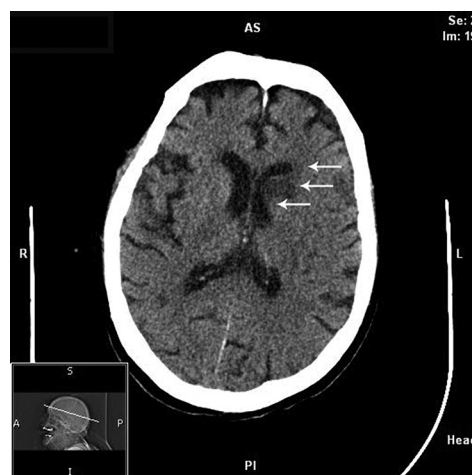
Noncontrast brain computed tomographic scan. Hypodensities apparent within right centrum semiovale, left anterior lentiform nucleus, left anterior capsule, and left caudate head. A indicates anterior; AS: anterosuperior; I: inferior; P: posterior; PI: posteroinferior; S: superior
